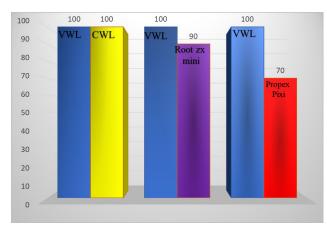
Accuracy of CBCT WL, Root ZX mini, and Propex Pixi when compared with Visual WL VWL: Visual Working Length CWL: CBCT Working Length
